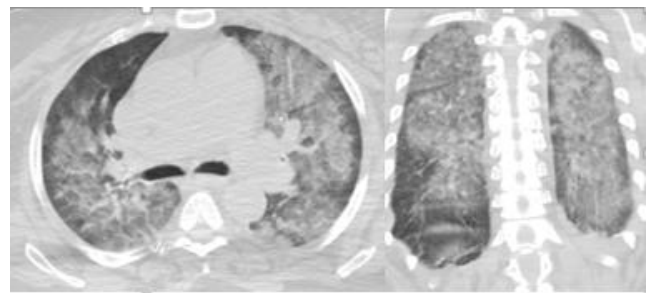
High-resolution computed tomography at the time of admission
